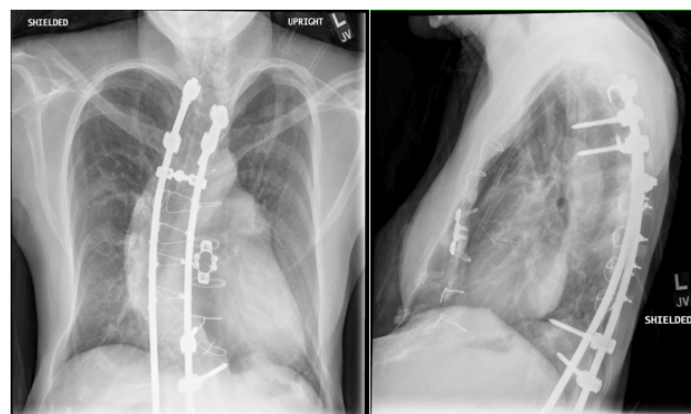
Admission chest x-ray demonstrating a prominent cardiomeastinal silhouette and tortuous thoracic aorta. The visualized sternotomy wires and screws are from the patient's aortic root and valve replacement two years prior.
